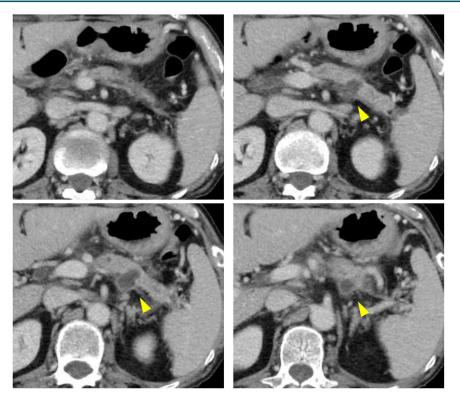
CT images of the pancreatic fistula. Pancreatic leakage associated with the fistula of the caudal main pancreatic duct. Yellow arrowheads indicate pancreatic fistula.
